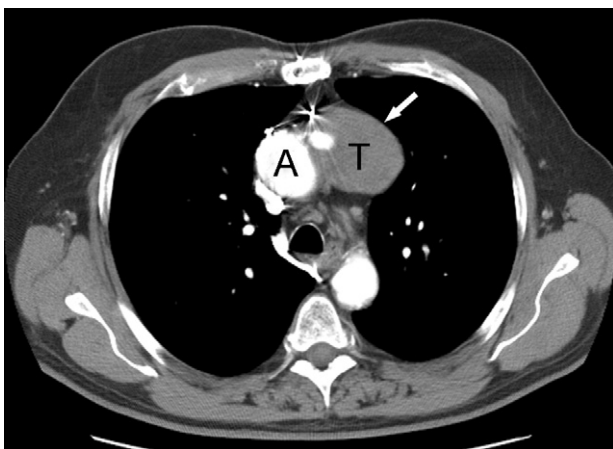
Computed tomography image shows aneurysmatic saphenous vein graft aneurysm (arrow) full of thrombus (T). (A = aorta).
